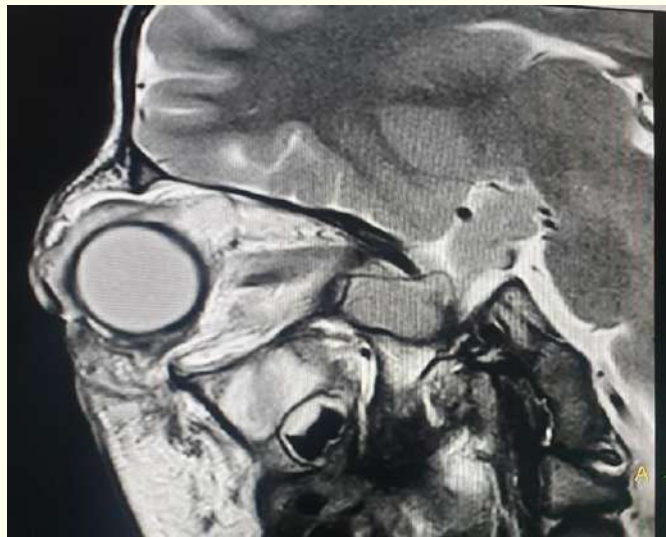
MRI Scan at presentation
